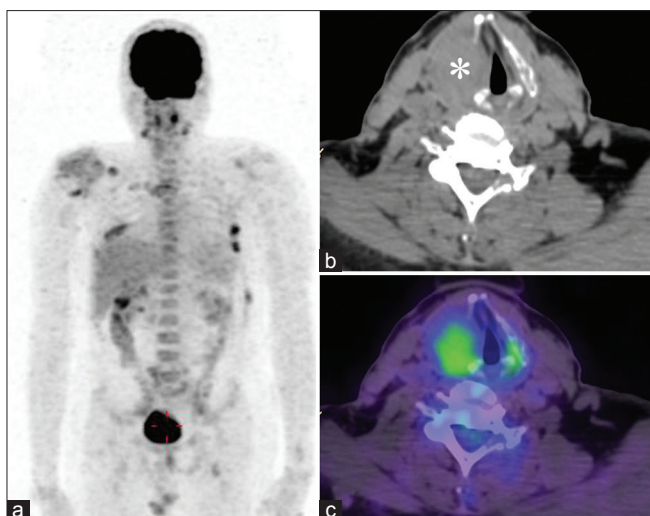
(a) Whole body maximum intensity projection showing multiple areas of increased abnormal metabolism including the right shoulder, ribs, thoracic vertebra, and in the neck on the right side. (b) Transaxial computed tomography image showing soft-tissue expansile lesion (*) in the right lamina of the thyroid cartilage. (c) Fused positron emission tomography/computed tomography image showing the lesion with increased fluorodeoxyglucose avidity. The lesion was also seen involving the upper pole of the right lobe of the thyroid gland
